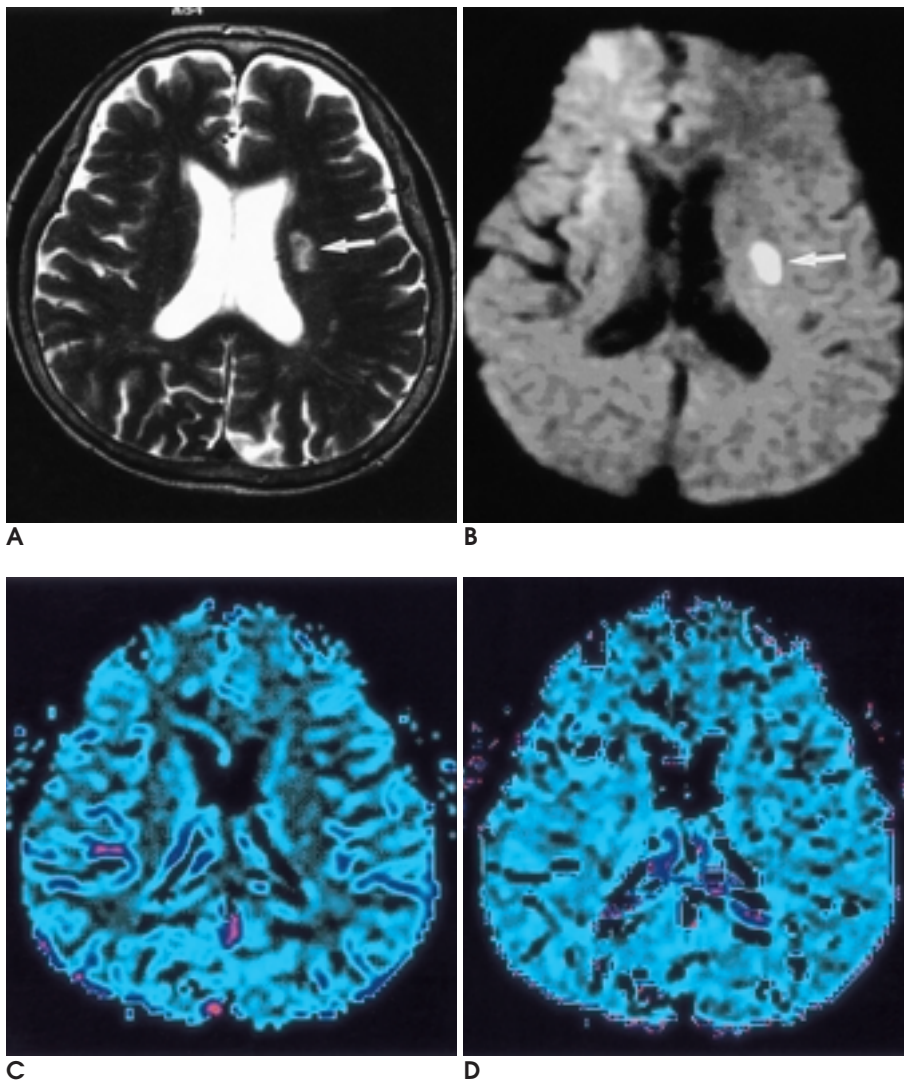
A 71-year old woman with small periventricular infarction. MR images were obtained 36 hours after symptom onset.
